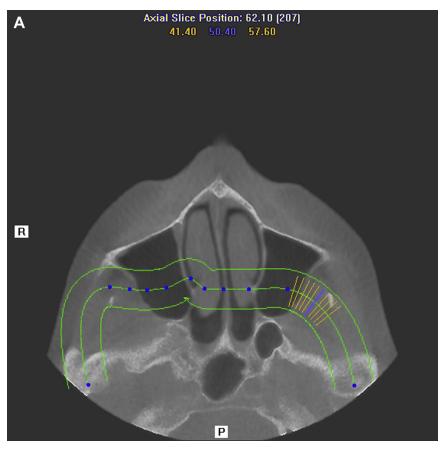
A, Computed tomography occlusal view revealing very little bone at the level of the sinus floor, demonstrating extreme maxillary atrophy. (Fig 2 continued on next page.)
